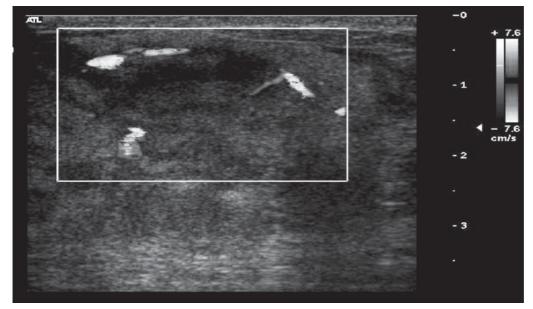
Color doppler sonography revealed an area with prominent vascularity in the upper quadrants of the left breast.
